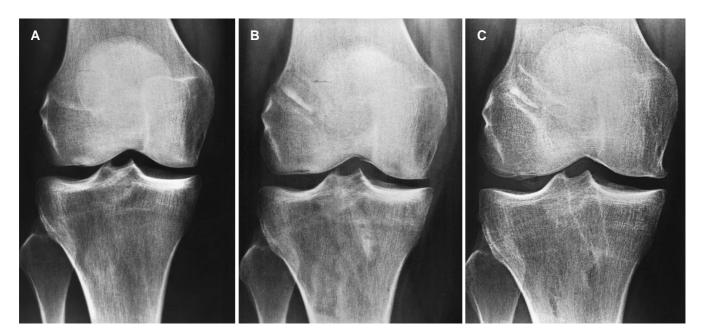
A–C Radiograph of the knee with SR-PLLA expansion plug used in fixation. Tibial and femoral drill channels were 9 mm in diameter and the drill channel for the plug 6 mm in diameter. A Preoperative radiography. B Postoperative radiography. C At 3-year follow-up, bone plugs are incorporated, and there is sclerosis at the bone channel margins
